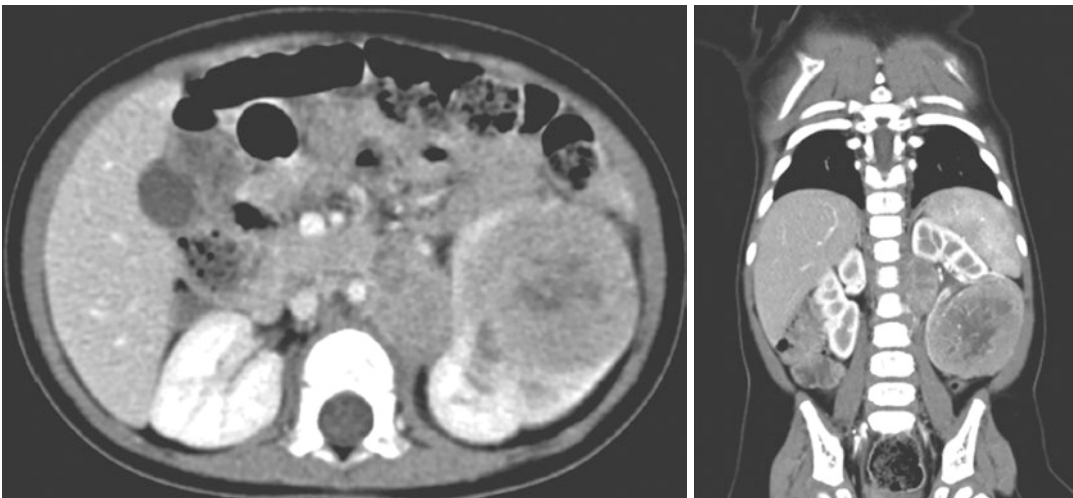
Post-contrast CT scan of a Xp11.2 translocation carcinoma in a 9-month-old baby girl
